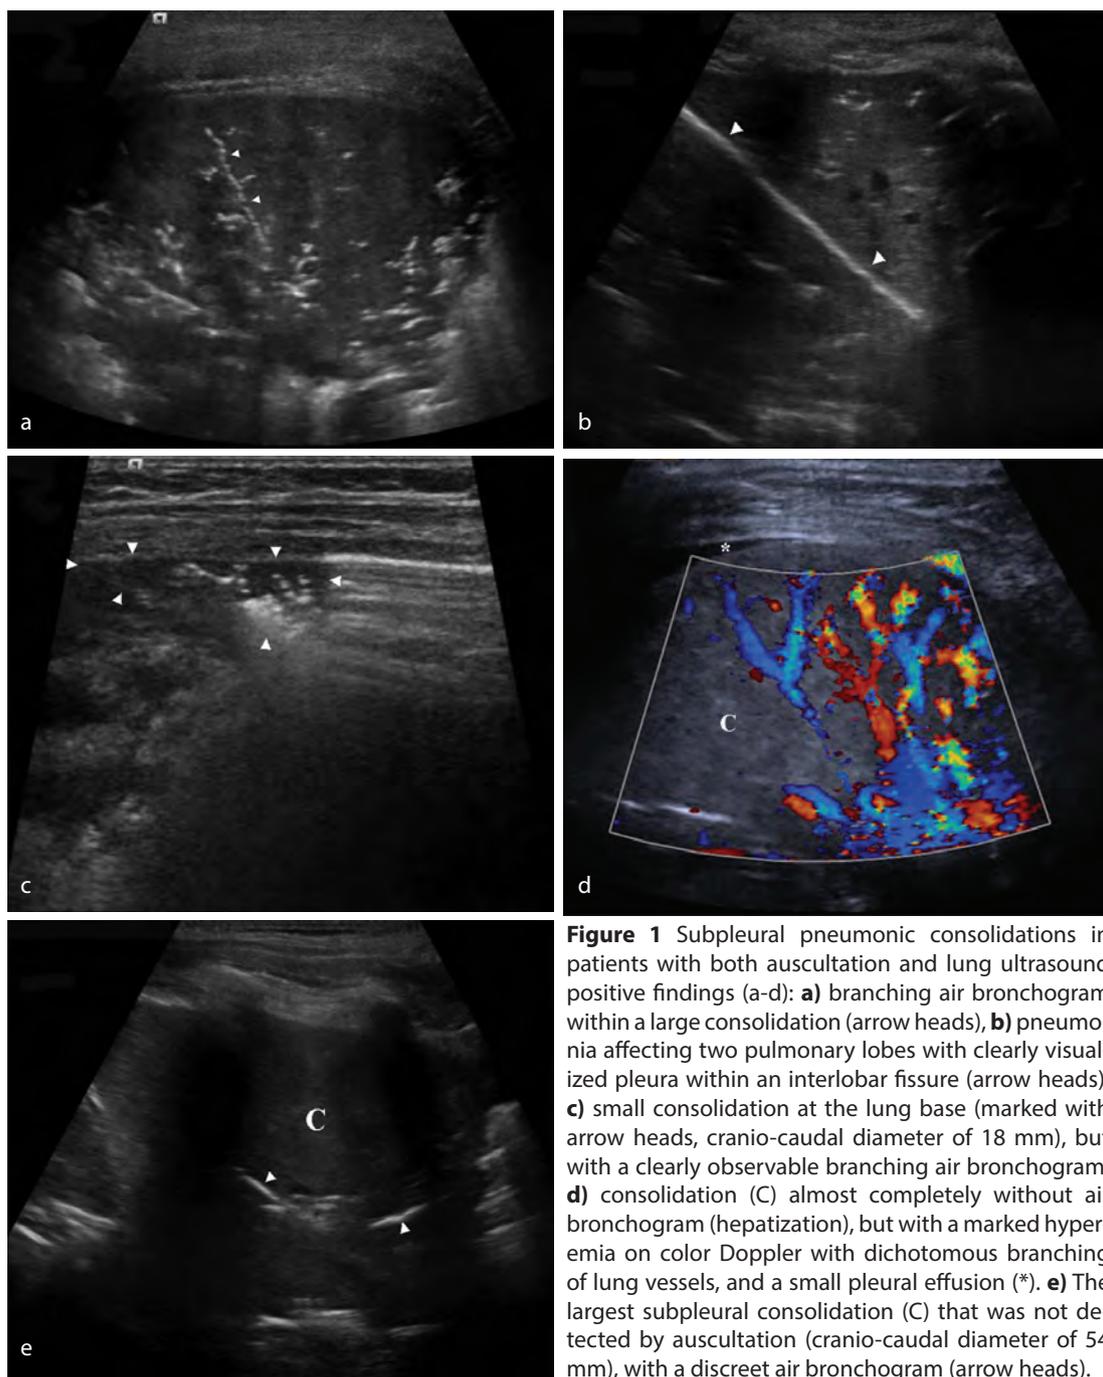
Subpleural pneumonic consolidations in patients with both auscultation and lung ultrasound positive findings (a-d): a) branching air bronchogram within a large consolidation (arrow heads), b) pneumonia affecting two pulmonary lobes with clearly visualized pleura within an interlobar fissure (arrow heads), c) small consolidation at the lung base (marked with arrow heads, cranio-caudal diameter of 18 mm), but with a clearly observable branching air bronchogram, d) consolidation (C) almost completely without air bronchogram (hepatization), but with a marked hyperemia on color Doppler with dichotomous branching of lung vessels, and a small pleural effusion (*). e) The largest subpleural consolidation (C) that was not detected by auscultation (cranio-caudal diameter of 54 mm), with a discreet air bronchogram (arrow heads).
